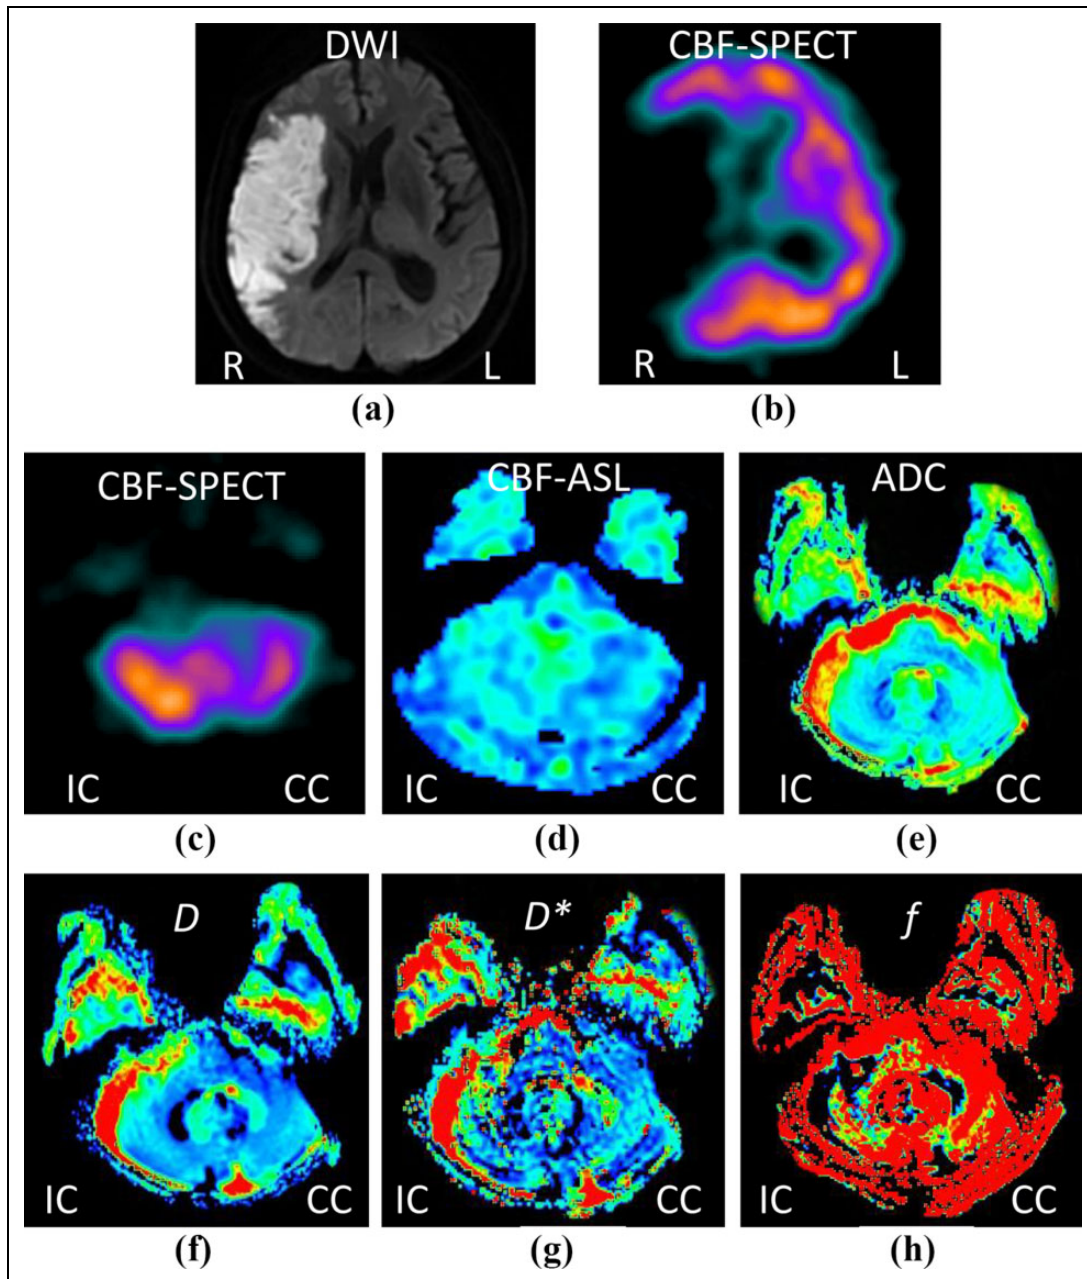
A 65-year-old man with supratentorial stroke in the right parietal for 10 days: hyperintensity stroke lesion can be recognized on the diffusion weighted image (DWI) ($b = 1000 \text{ sec/mm}^2$) (a). SPECT maps show hypoperfusion in the same lesion (b). SPECT maps (c) and ASL imaging (d) show hypoperfusion in the contralateral cerebellum. The IVIM-derived ADC (e) and D (f) maps have no change between the ipsilesional cerebellum and the contralateral cerebellum, whereas D^* (g) and f (h) values show a difference in the ipsilesional cerebellum compared with those in the contralateral hemisphere. CCD: crossed cerebellar diaschisis; CBF: cerebral blood flow; SPECT: single-photon emission computed tomography; ASL: arterial spin-labeling MR imaging; IC: ipsilateral cerebellum; CC: contralateral cerebellum; ADC: the apparent diffusion coefficient; D: slow diffusion coefficient; D^* : fast diffusion coefficient; f : vascular volume fraction.
